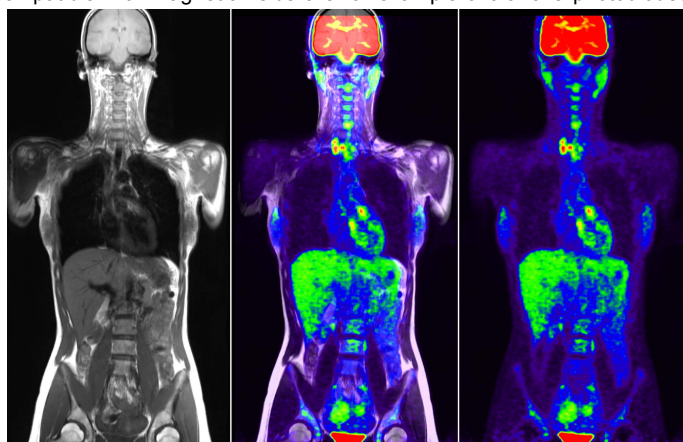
Hybrid whole-body PET/MRI dataset. T1 TSE (left), <sup>18</sup>F-FDG PET (right), fused PET/MRI dataset (center).
